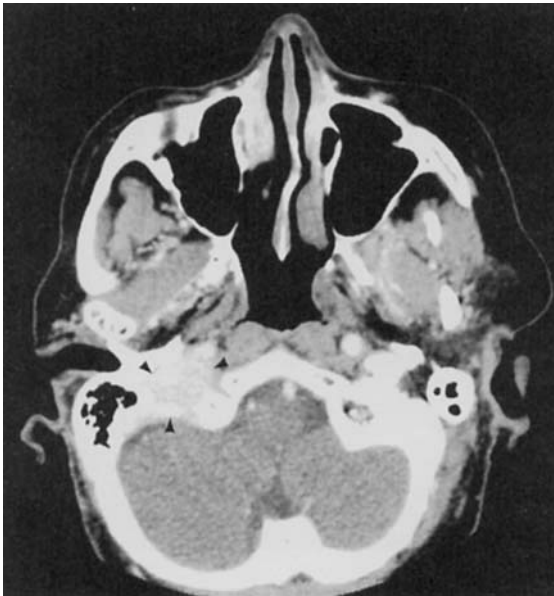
Glomus jugulare. Axial postcontrast CT scan reveals an enhanced mass (*arrowheads*) at the right jugular foramen. Bone window images reveal jugular foramen erosion characteristic of glomus jugulare (versus smooth enlargement of the foramen associated with schwannomas and meningiomas).
